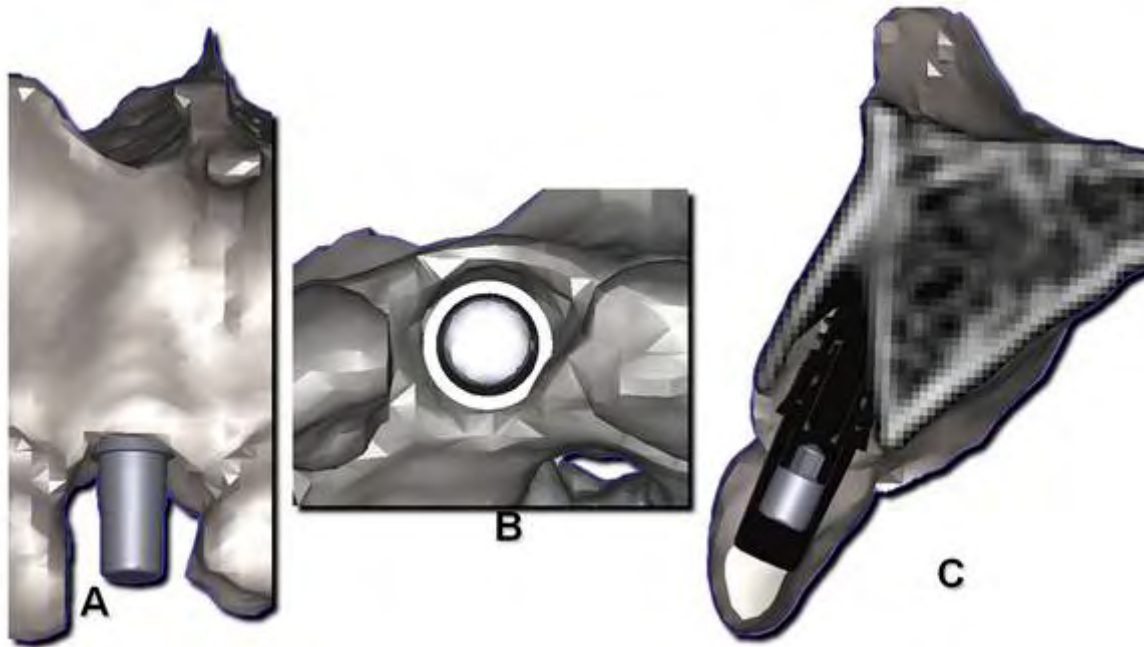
3D CT-based model of an upper central incisor extraction socket and an implant model positioned inside of the alveolus. A – Frontal view. B – Occusal view. C – Proximal view.
